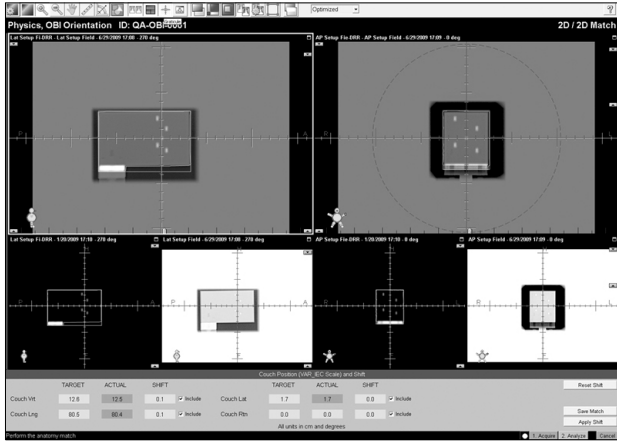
Two-dimensional-two-dimensional (2D/2D) matching software on the On-Board Imaging workstation. Lateral and anterior digitally reconstructed radiographic (DRR) images were overlaid on each 2D kV portal image.
